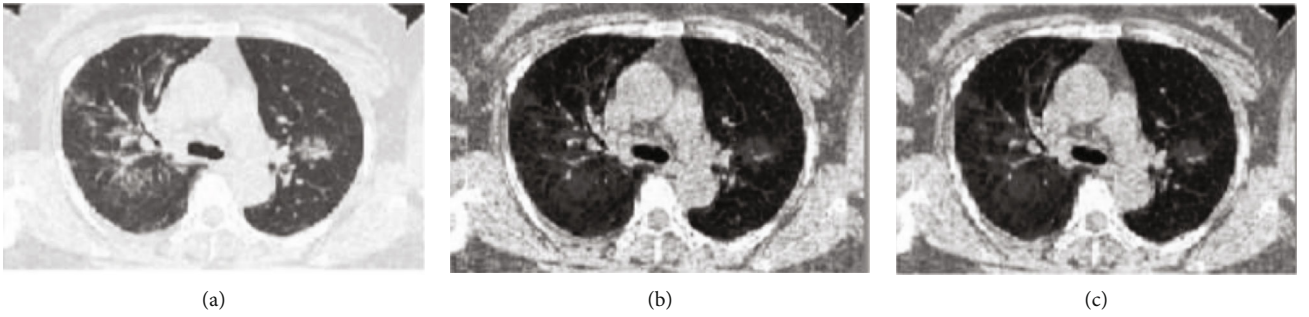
(a) Original COVID-19 CT scan image (b) Histogram equalized COVID-19 CT scan image (c) Weiner filtered COVID-19 CT scan image.
